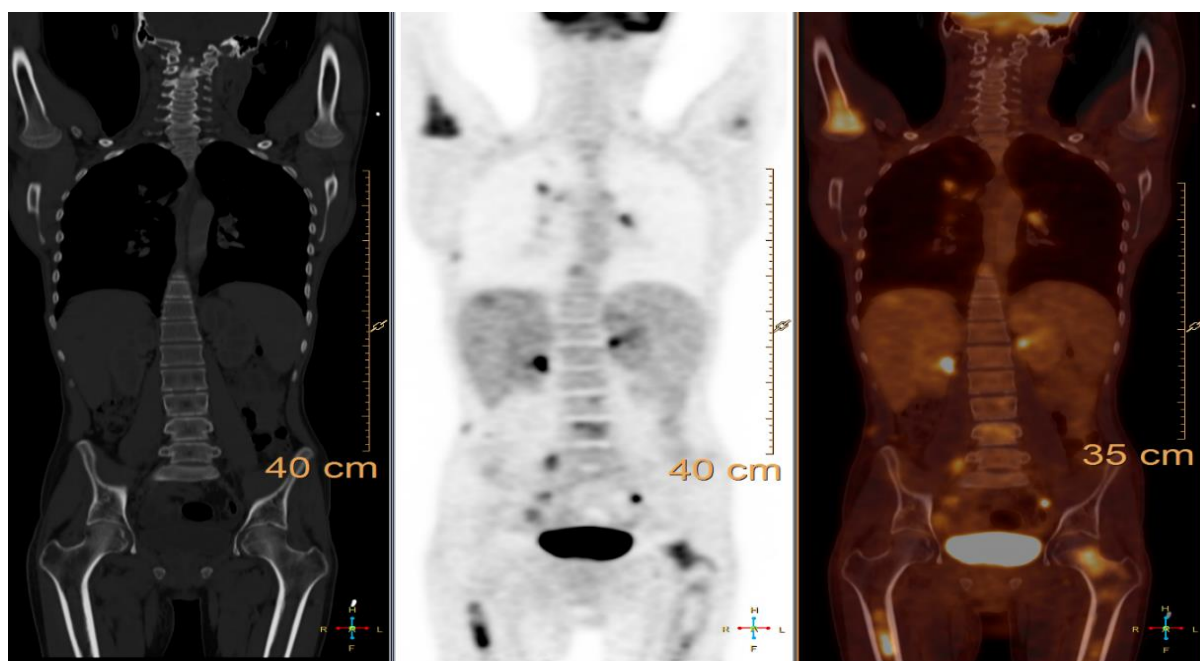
34 years old male with non seminomatous testicular cancer. Follow up PET/CT shows multiple metastatic pleuro-pulmonary, nodal, hepatic, pancreatic and osseous deposits.
